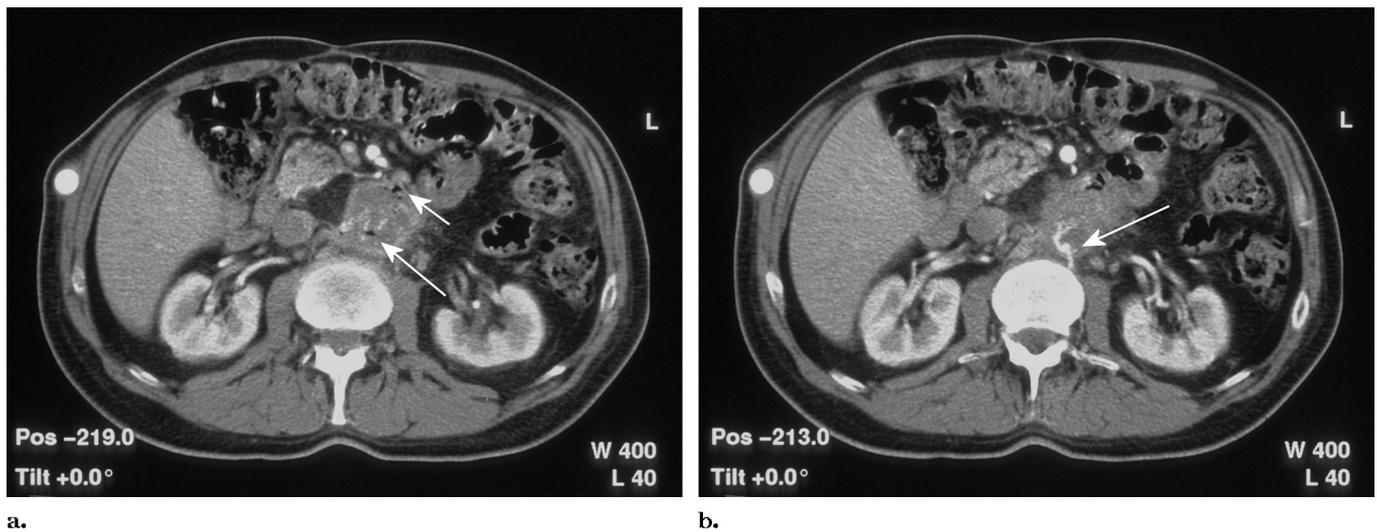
Contrast material–enhanced CT scan demonstrates that the aortic graft has been removed and a right axillobifemoral graft is present. (a) A contrast material–filled, thin, irregular fistulous tract is seen between the distal end of the aortic stump and the duodenum. Note the presence of gas pockets within the abscess cavity (long arrow) and the duodenum anteriorly (short arrow). (b) An enhancing lumbar artery is seen communicating with the aortic stump abscess cavity posteriorly (arrow).
